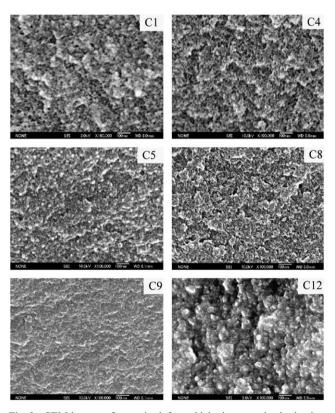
SEM images of resorcinol-formaldehyde sonogels obtained at different C/W ratios (mol m⁻³) and different ultrasonic intensities $(W \text{ cm}^{-2})$: C1 and C4 (C/W = 20, I = 0 and 106, respectively); C5 and C8 (C/W = 40, I = 0 and 106, respectively); C9 and C12 (C/W = 80,I = 0 and 106, respectively). Reprinted with permission from ref. 26: N. Tonanon, A. Siyasukh, W. Tanthapanichakoon, H. Nishihara, S. R. Mukai and H. Tamon, Carbon, 2005, 43, 525. Copyright 2005 Elsevier Ltd.
